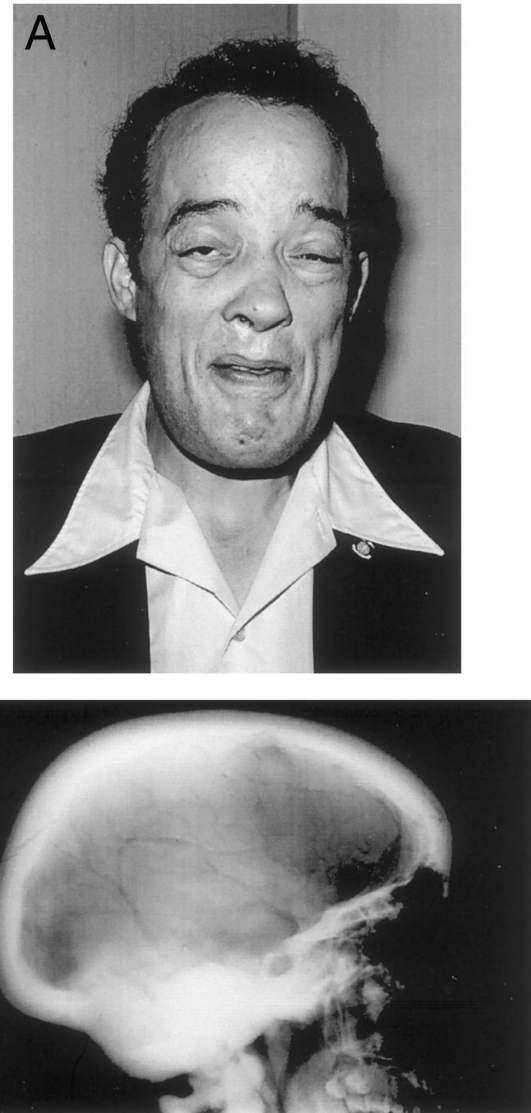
Clinical manifestations of sclerosteosis. *A*, An adult Afrikaner with the characteristic mandibular overgrowth, facial palsy, and deafness. *B*, Lateral radiograph of the skull of an affected adult Afrikaner. Gross hyperostosis of the calvarium and base are evident.
